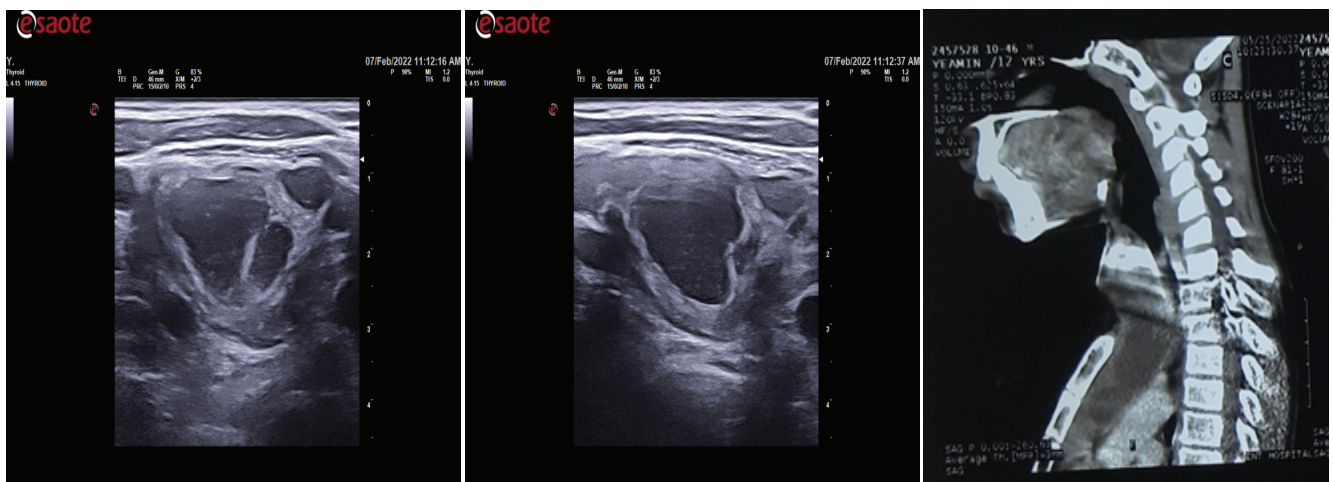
US and CT image showing cystic and dense mass extending into mediastinum.
